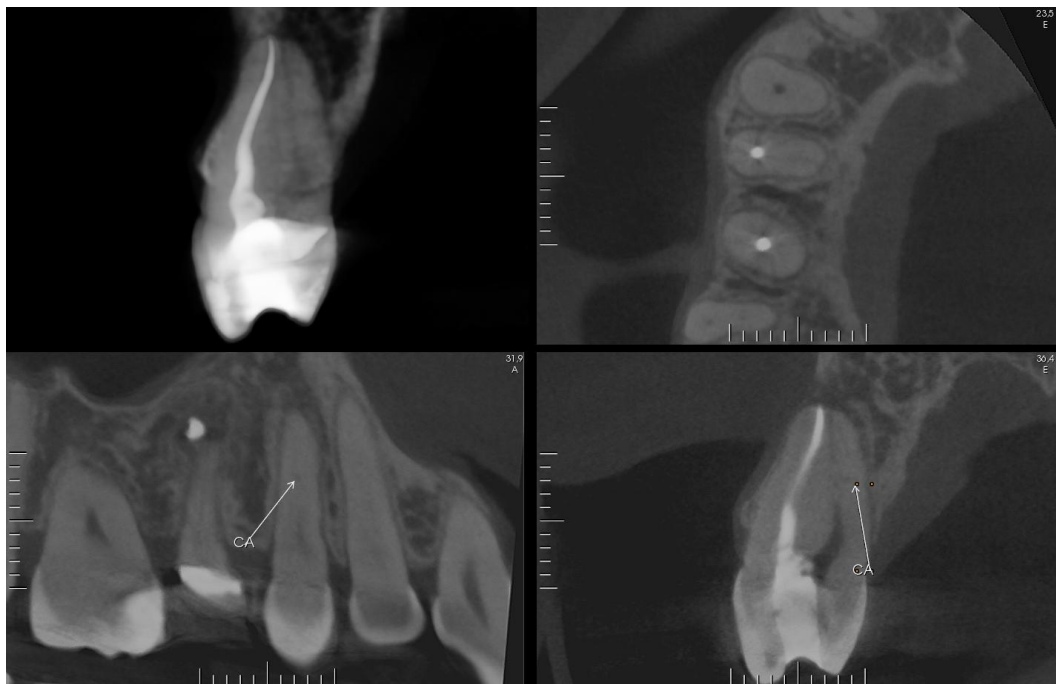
Multiplanar CBCT views and 3D reconstruction of a representative case showing exclusively apical bone resorption.
